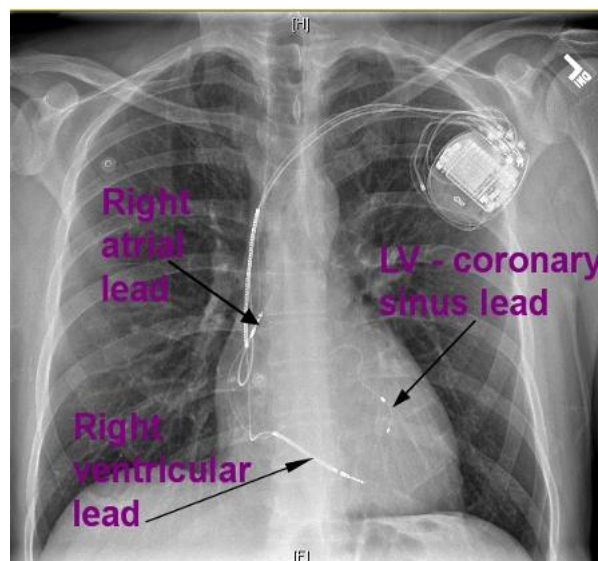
Chest X-ray of a patient with a CRT-D
